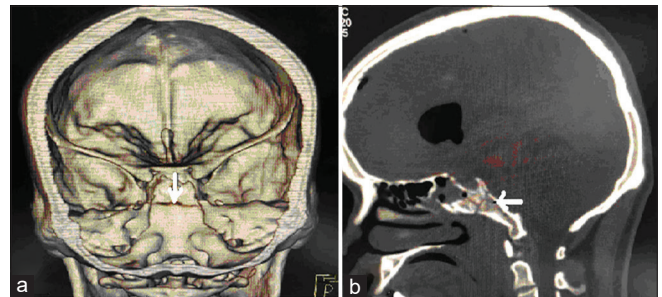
(a & b). Computed Tomography of skull showing linear undisplaced clival fracture
